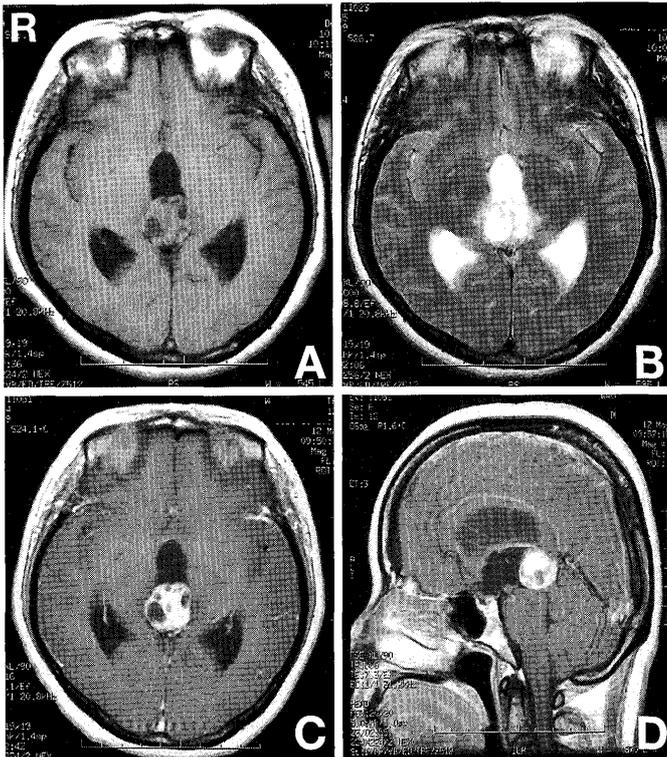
A: T₁-weighted magnetic resonance (MR) image showing the solid component of the pineal tumor as isointense with some cystic components, and apparently causing obstructive hydrocephalus. B: T₂-weighted MR image showing the tumor as hyperintense. C: T₁-weighted MR image with contrast medium showing the solid and partly cystic tumor with regions of enhancement. D: Sagittal T₁-weighted MR image with contrast medium.
